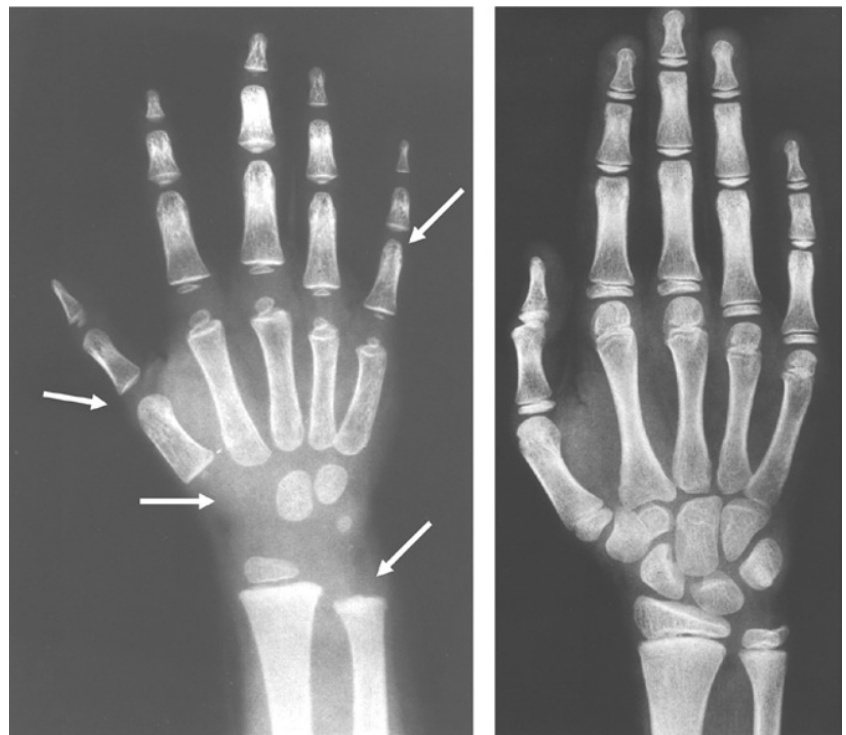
Two radiographs of the left hands of two healthy children. Note that the mineralization of the small bones has not yet occurred in the younger child (left).
